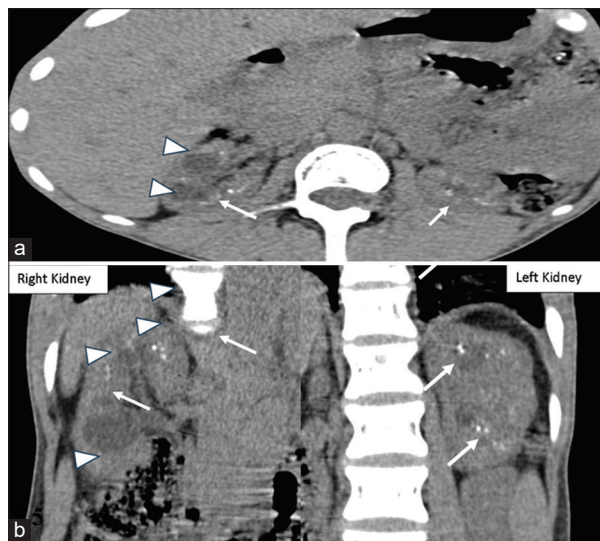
(a) Non-contrast computed tomography (CT) scan (axial section) showing bilateral medullary nephrocalcinosis (white arrows) with cysts in the right kidney (arrowhead), (b) Non-contrast CT Scan (coronal section) showing bilateral medullary nephrocalcinosis (white arrows) with cysts in the right kidney (arrowhead) (Case 2)
